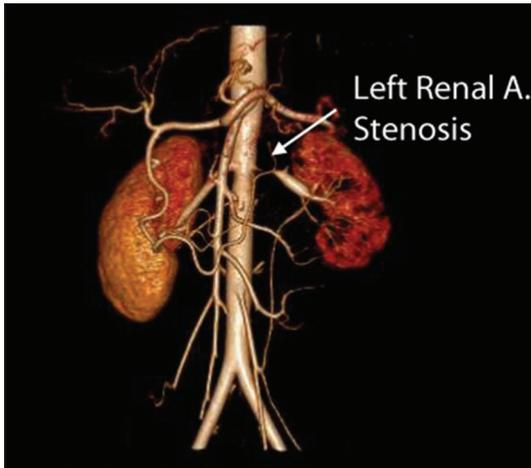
Computed tomography angiogram revealed diffuse thickening and enhancement of aortic wall and its major branches along with critical narrowing of the ostium of left renal artery
